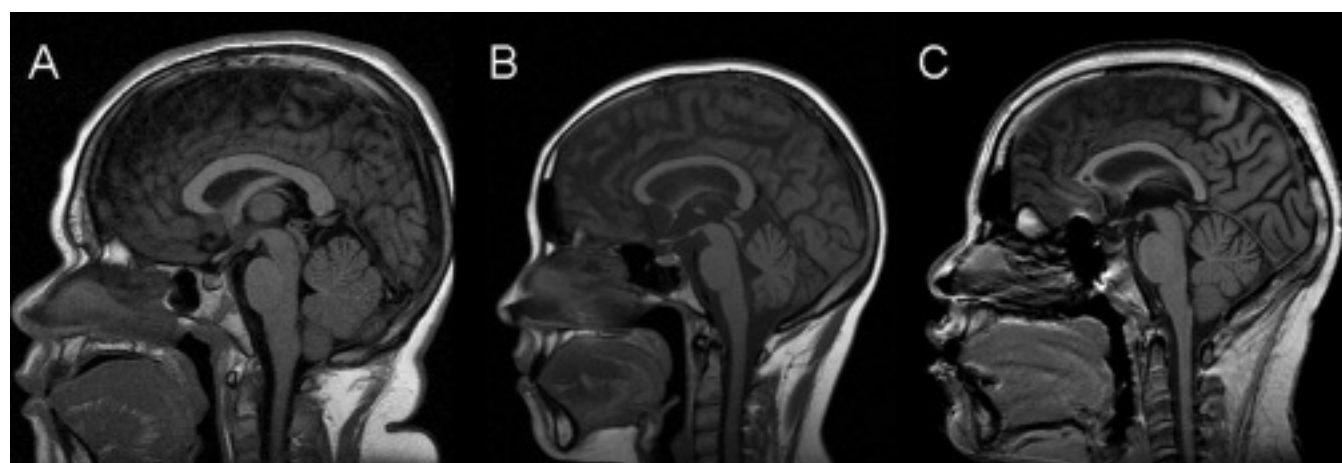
Assessment of corpus callosum thickness. A. Sagittal T1-weighted image showing intact corpus callosum appearance with a thickness of 7.5 mm at the level of the junction of the anterior body and genu in a 19-year-old male with protracted disease and recent transient ischemic attack. B. Uniform thinning of the corpus callosum with a thickness of 5.0 mm at the same location in a 20-year-old female with protracted disease, multiple episodes of NPSLE, and recent lower extremity weakness. C. Uniform thinning of the corpus callosum with a thickness of 4.2 mm at the same location in a 14-year-old girl with protracted disease course and acute confusional state and psychosis. Note T1 focal hypointense lesion in genu.
